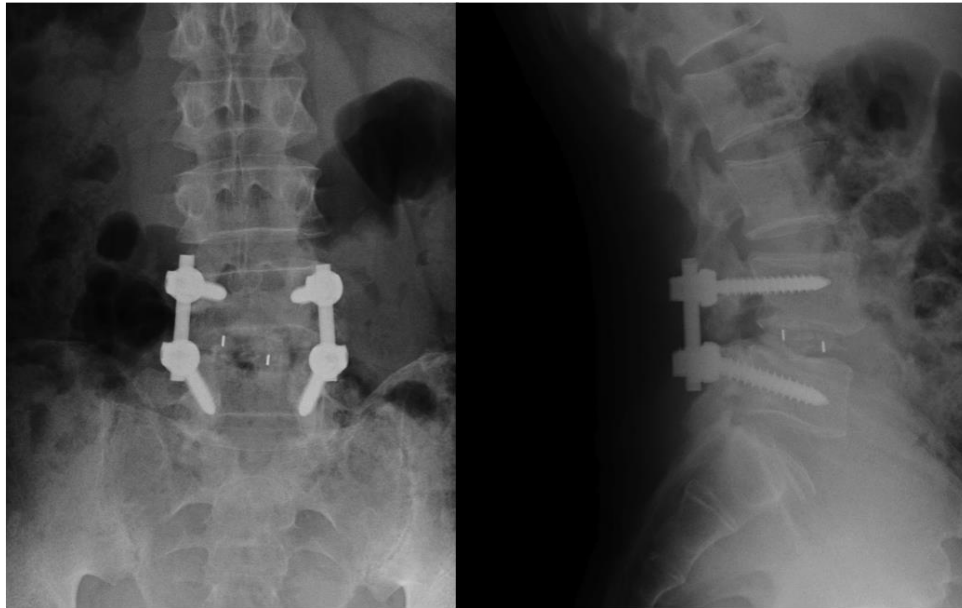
X-radiographs show the fusion meet 3 criteria: bony continuity between endplates, trabecular structure in anterior bone bridge and lack of radiolucent lines around implants.
